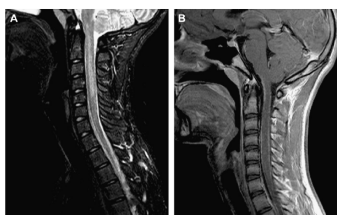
Spinal MRI of Case 2 shows (A) a lesion ranging from the pons down to C5 in the sagittal T2-weighted image and (B) leptomeningeal contrast enhancement in the sagittal T1-weighted image.
